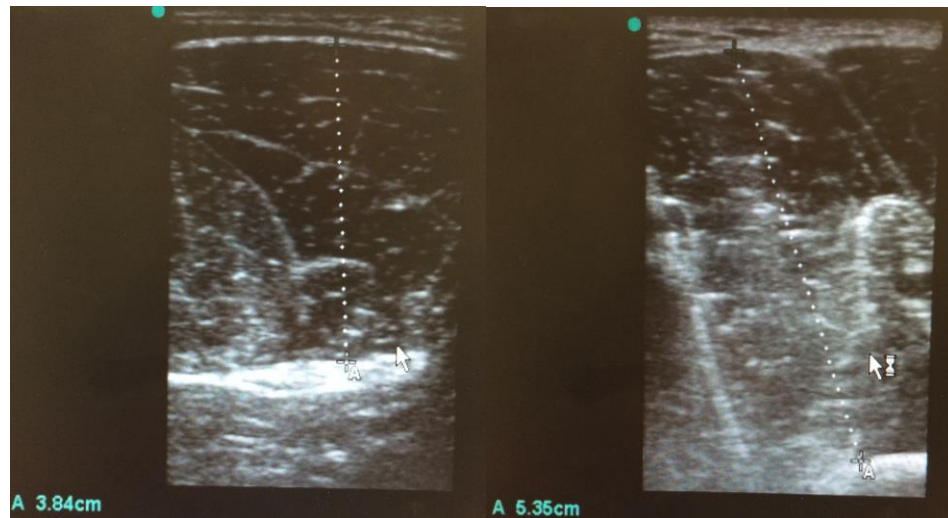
Positions for Ultrasound Assessment of Thigh Muscle Thickness
